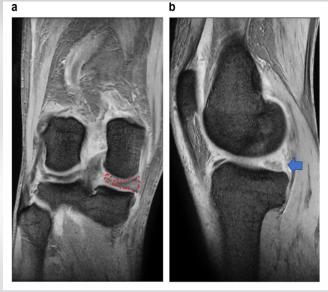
T2-weighted magnetic resonance imaging of the right knee. (a) coronal image showing a giraffe neck sign (red dotted line). (b) Sagittal image showing a white meniscus sign (blue arrow).
